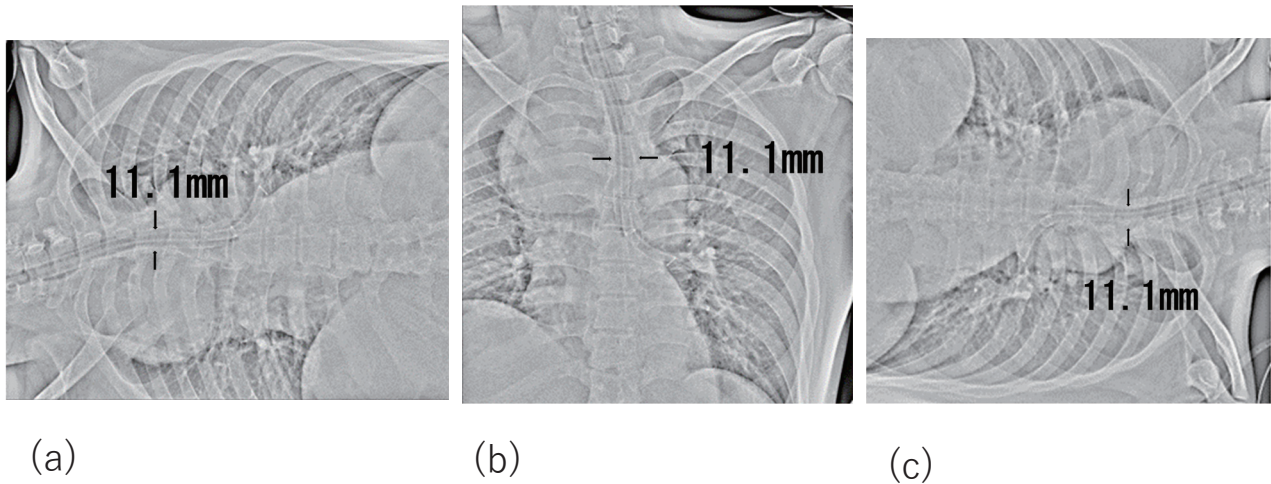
(a) Radiograph after intubation, right lateral position. (b) Radiograph after intubation, supine position. (c) Radiograph after intubation, left lateral position.
